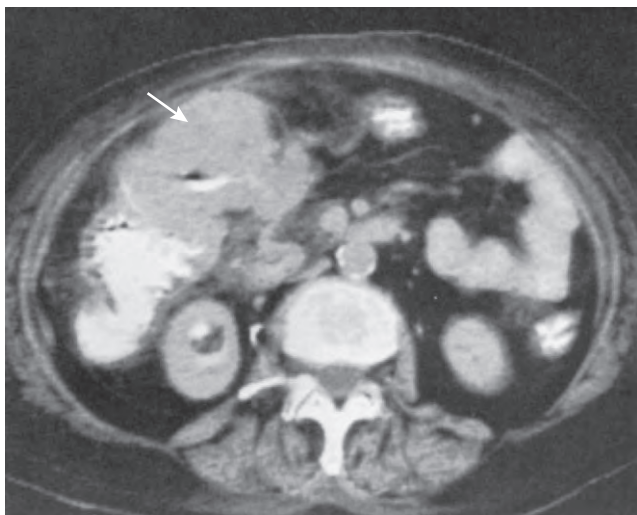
Abdominal CT scan showing carcinoma of hepatic flexure of the colon (*arrow*). (Courtesy of Ruedi F. Thoeni, MD.)
